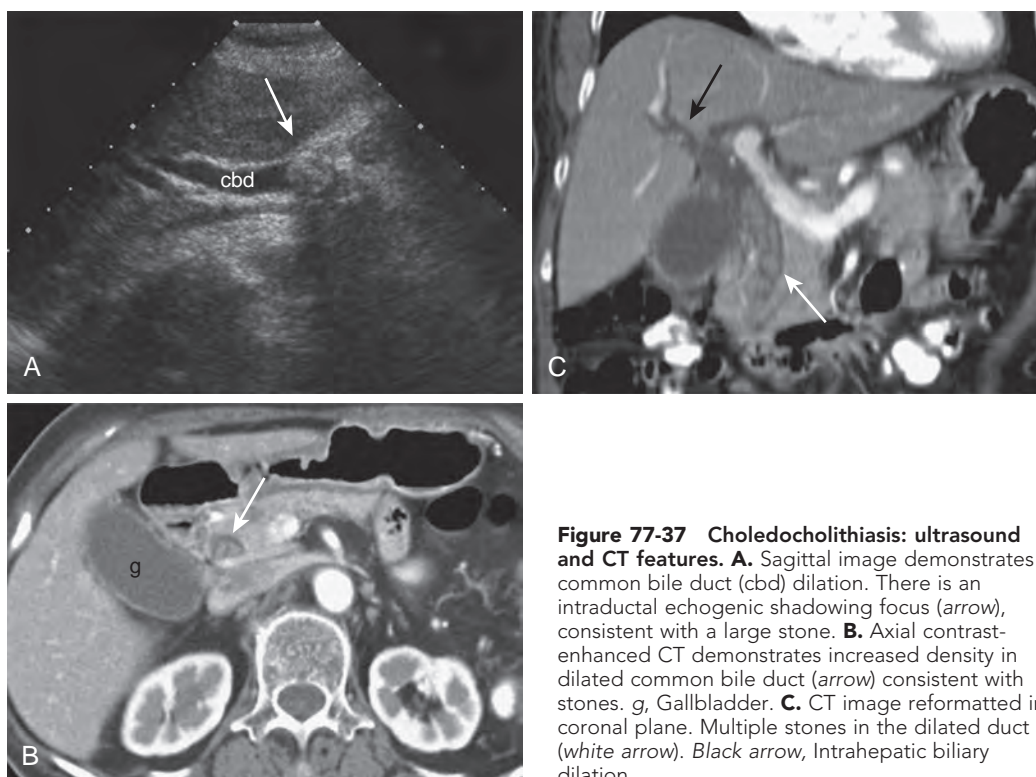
Choledocholithiasis: ultrasound and CT features. A. Sagittal image demonstrates common bile duct (cbd) dilation. There is an intraductal echogenic shadowing focus (arrow), consistent with a large stone. B. Axial contrast-enhanced CT demonstrates increased density in dilated common bile duct (arrow) consistent with stones. g, Gallbladder. C. CT image reformatted in coronal plane. Multiple stones in the dilated duct (white arrow). Black arrow, Intrahepatic biliary dilation.
